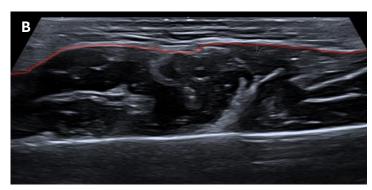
Ultrasound examination of the masseter muscle without (A) and with (B) clenching, revealing a bulging of the superficial portion, exacerbated upon clenching.
